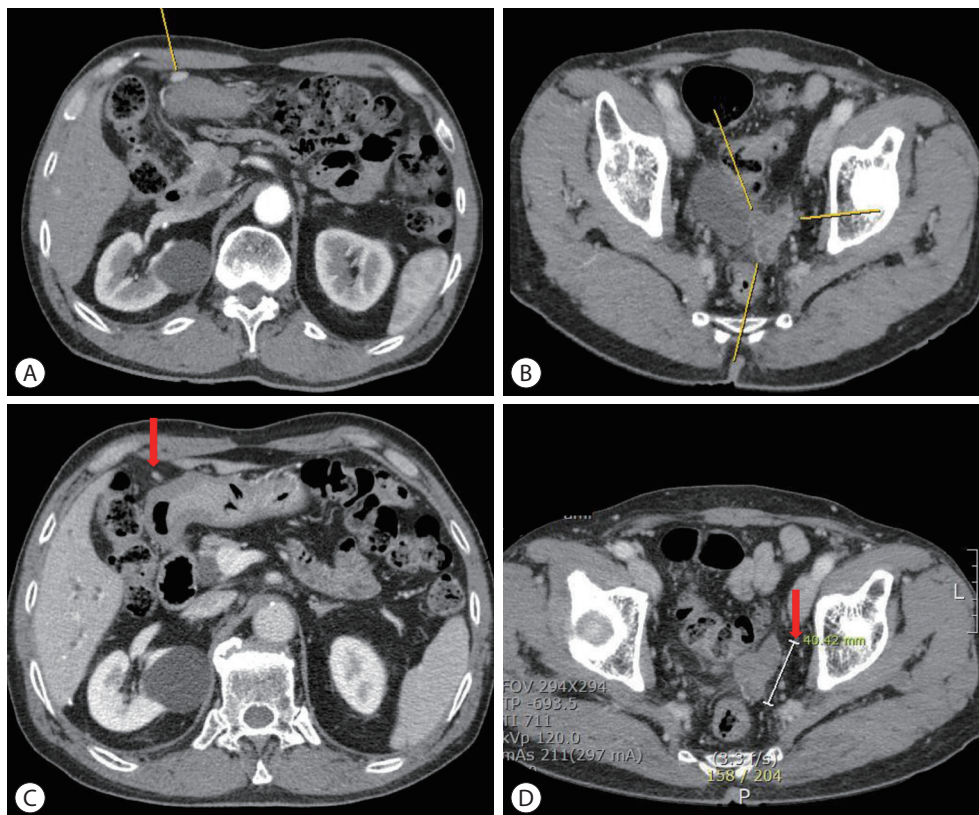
Follow-up liver dynamic computed tomography (CT) imaging findings before and after systemic therapy: the recurrence of peritoneal metastases. (A) Liver dynamic CT, arterial phase, right upper quadrant area on abdominal cavity (yellow line) on June 2020. (B) Liver dynamic CT, arterial phase, rectovesical pouch (yellow line) on June 2020. (C) Liver dynamic CT, arterial phase, right upper quadrant area on abdominal cavity (red arrow) on June 2021 after 33 cycles of atezolizumab and bevacizumab combination therapy. (D) Liver dynamic CT, arterial phase, rectovesical pouch (red arrow) on June 2021 after 33 cycles of atezolizumab and bevacizumab combination therapy.
